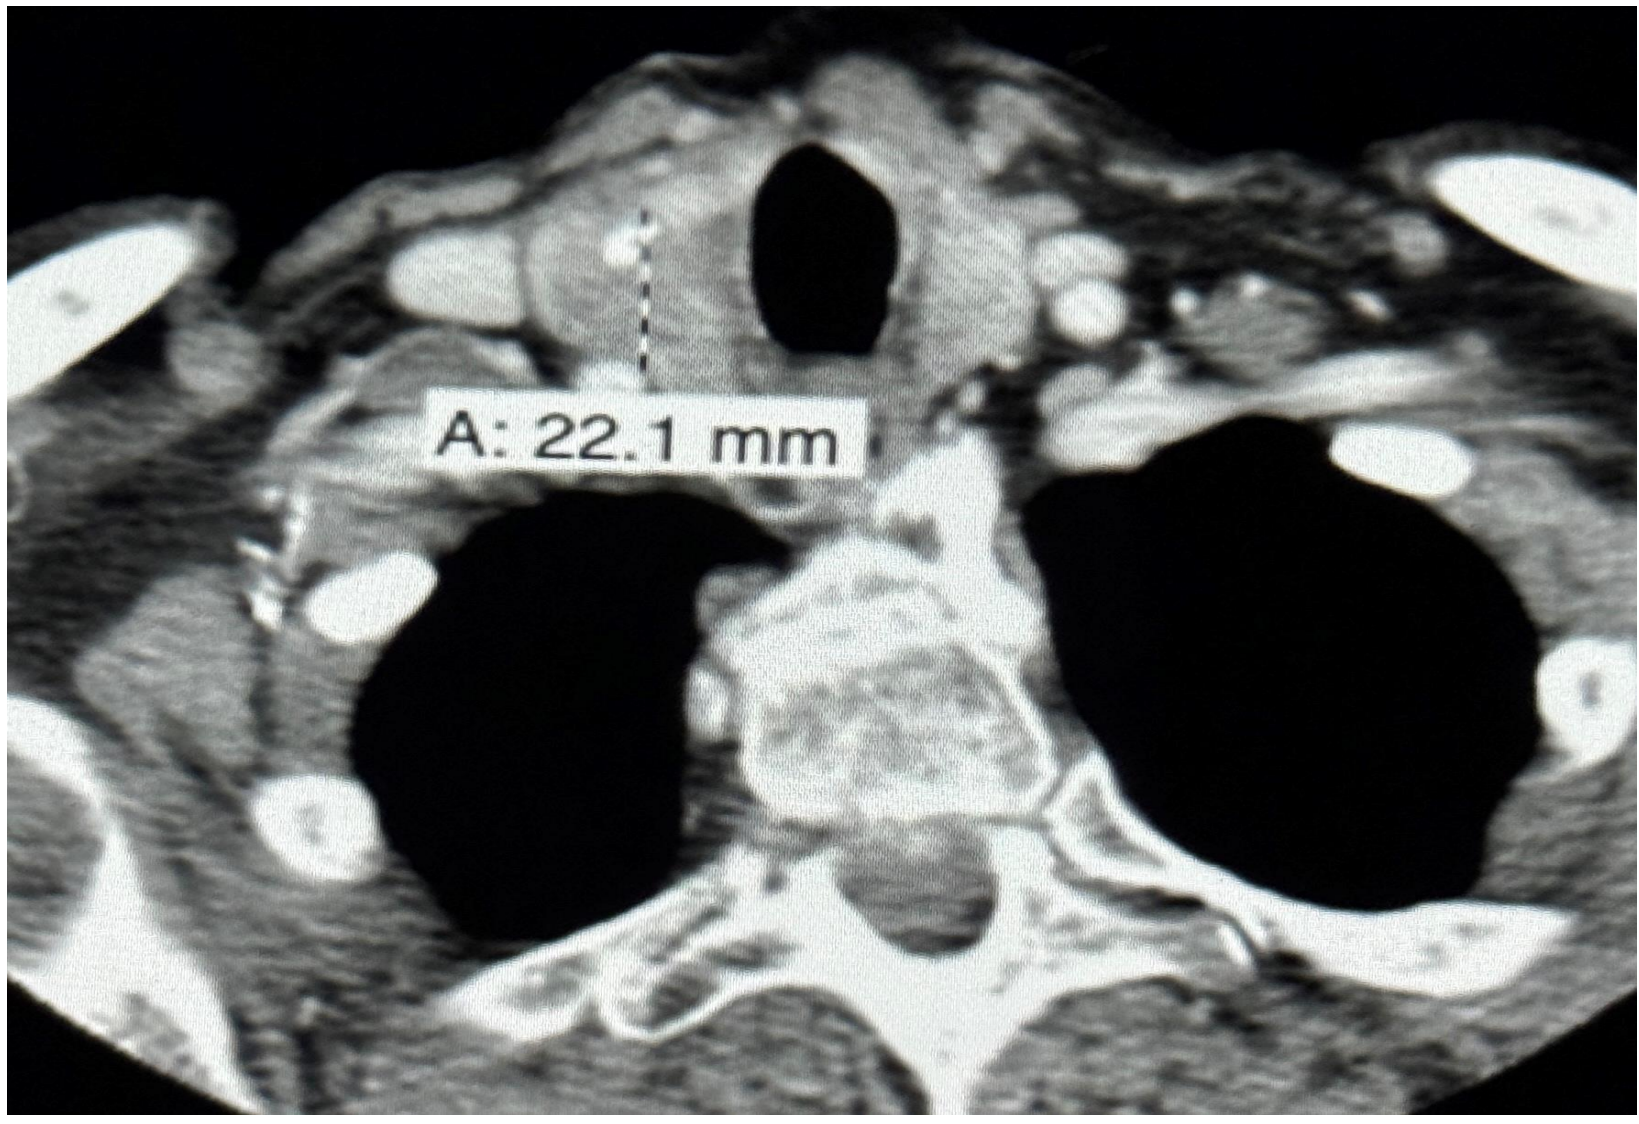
CT soft tissue neck with IV contrast demonstrating 2.2 cm right thyroid mass with internal calcification (A, above), suggestive of PTC.
